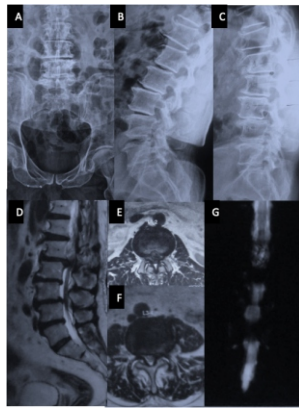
Figure (A, B, C) Radiographs showing degenerated lumbar spine with L3/4 anterolisthesis, L2/3 and L1/2 retrolisthesis, multiple Knupton's signs and osteoporosis. (D, E, F) MRI with L1/2 sequestered big central disc prolapse, multilevel and L3/4 major facet arthrosis and stenosis. (G) MR myelogram showing complete myelo-block at L1/2 and L3/4 level.
